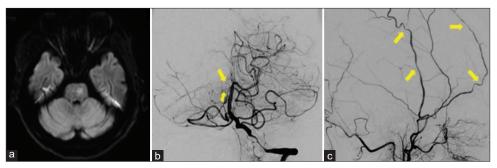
(a) Diffusion-weighted magnetic resonance imaging revealed a new cerebral infarction in the left pons. (b) In the front view of digital subtraction angiography (DSA), the right posterior cerebral artery and the right superior cerebellar artery showed laminar flow (arrow) due to blood flow through the right posterior communicating artery, and blood flow from the left vertebral artery was predicted to be reduced. (c) The lateral view of DSA revealed a narrowing of the superficial temporal artery at multiple sites (arrow).
